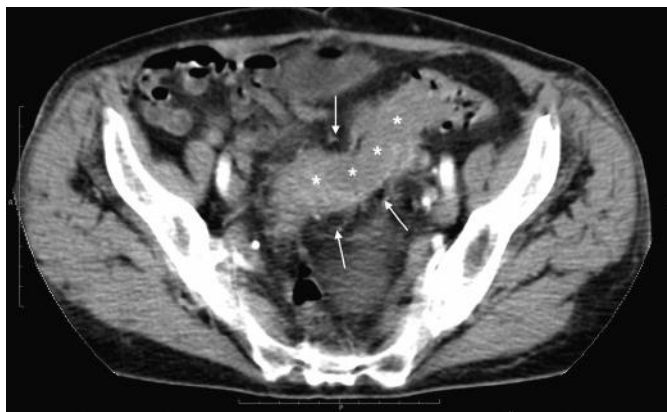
X – CT axial slice showing the fluid filled sigmoid colon lumen (asterisks) and the outpouching sigmoid diverticula (arrows).
